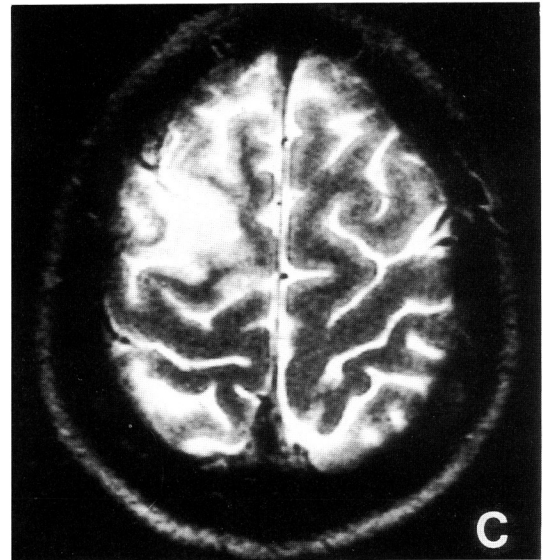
MRI taken on the day of admission. Gadolinium enhanced T1-weighted image(A and B) demonstrated inflammatory mucosal thickening in the left maxillary and anterior ethmoid sinuses. Sphenoid sinus appeared to be normal. T2-weighted axial image of brain(C) revealed a focal area of high signal density in the right frontal lobe, which must be due to venous infarction.
